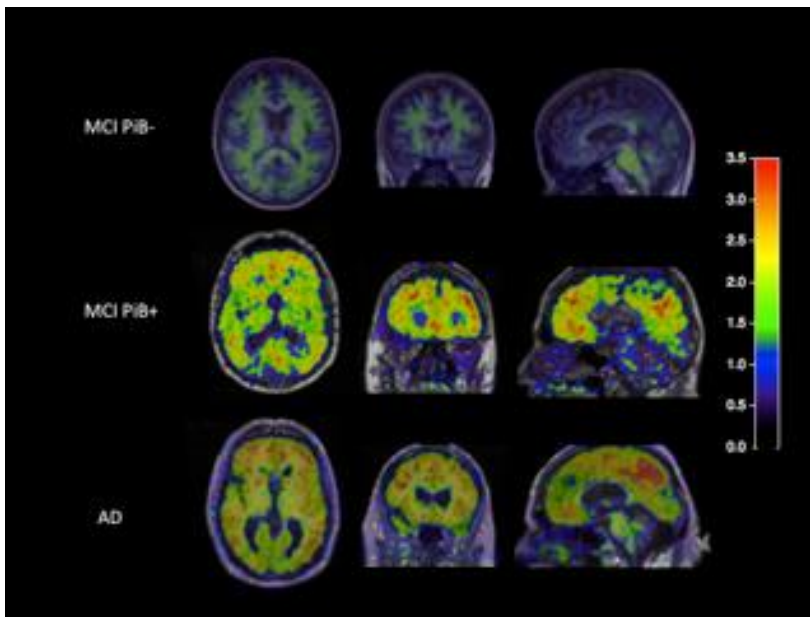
Fusion images from co-registered PET and MRI scans. Deposition of fibrillar amyloid plaques measured with ^{11}C -PIB PET in two patients with MCI and one patient AD. The fusion images are presented in transverse (left panel), coronal (middle panel) and sagittal (left panel) sections. The MCI patients were clinically longitudinally followed. The MCI patient with low PIB retention (PIB negative) remained as MCI while the MCI patient with high PIB retention (PIB +) converted to AD. Standard uptake values (SUV) in relation to cerebellum are expressed in colour scale.
